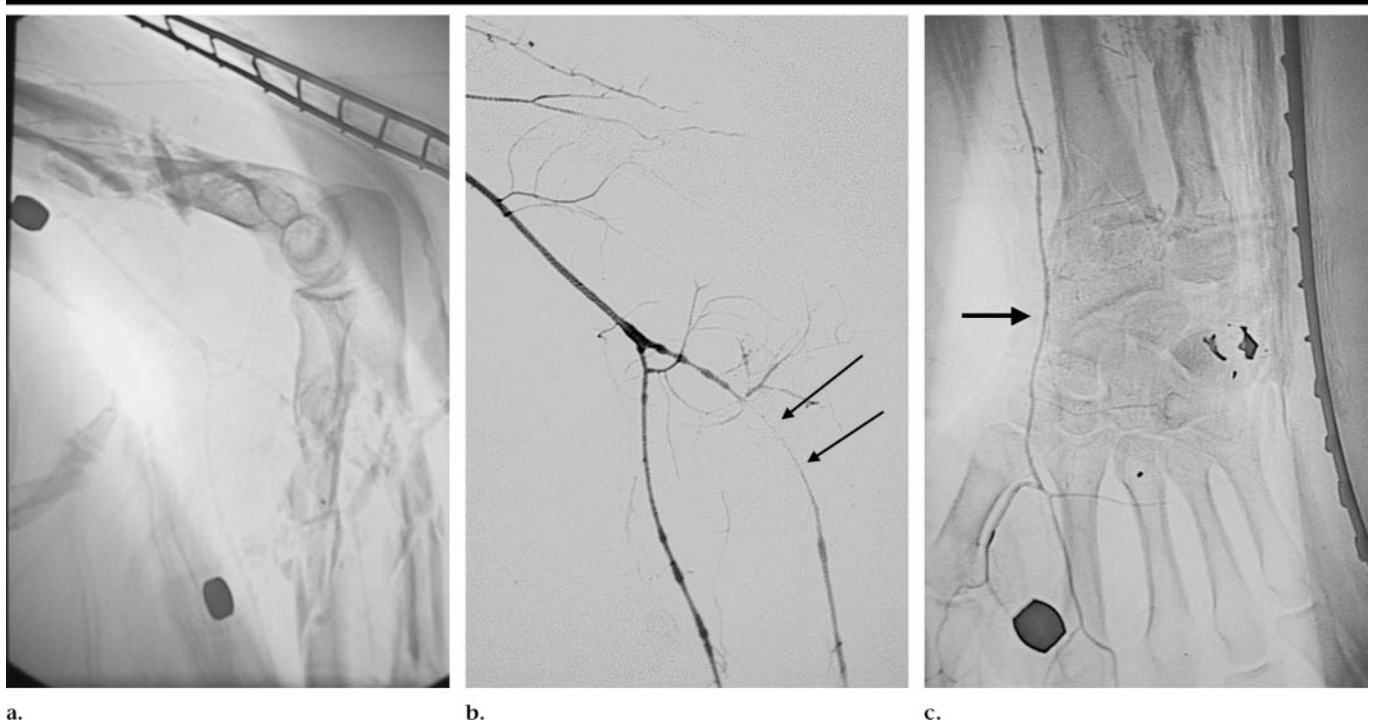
Multiple soft-tissue injuries to the left arm and hand of a 40-year-old terror attack victim. (a) Lateral radiograph of the arm shows shrapnel and comminuted fractures of the humerus, radius, and ulna. (b) Lateral digital subtraction angiogram of the arm demonstrates spasm (arrows) of the vessels, without bleeding. (c) Anteroposterior nonsubtracted angiogram of the hand shows multiple shrapnel and a thin radial artery (arrow).
